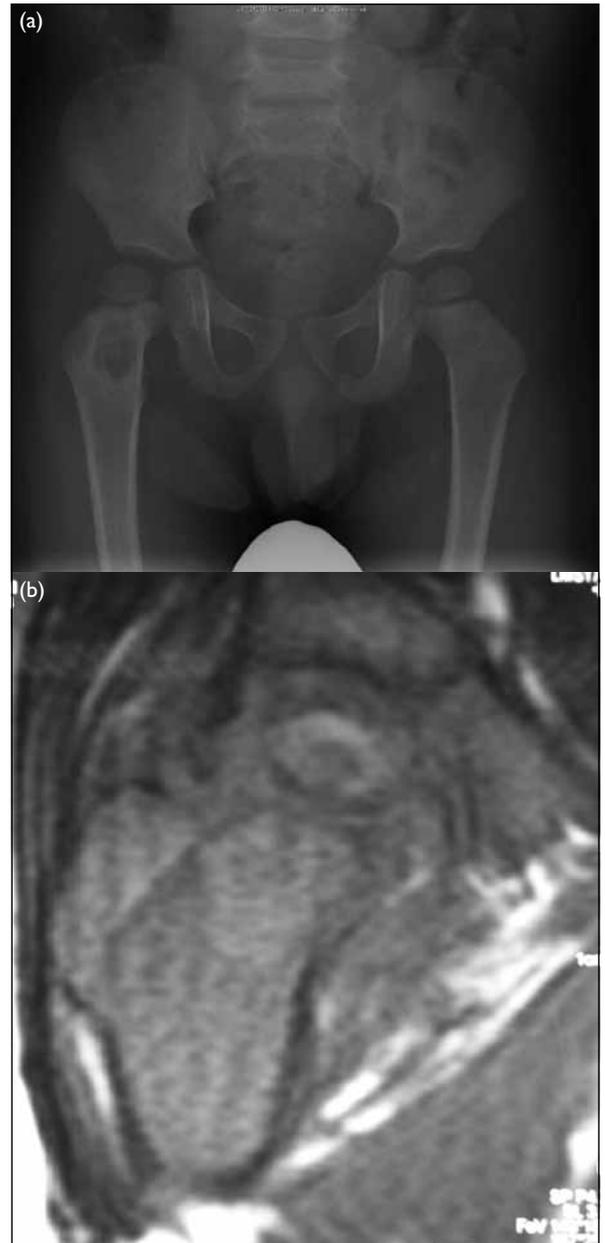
(a) Pelvis X-ray showing an osteolytic lesion over the metaphyseal region of the right proximal femur. (b) Magnetic resonance image of the right proximal femur showing inflammation around the proximal femur and within the medullary canal
